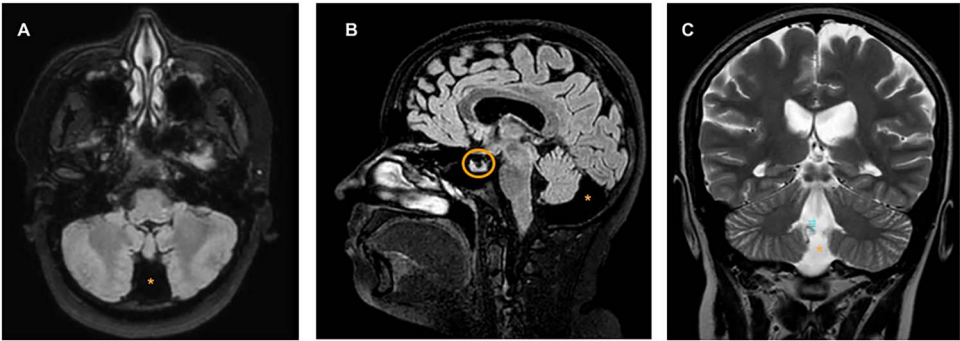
Brain magnetic resonance imaging without contrast axial fluid-attenuated inversion recovery (FLAIR) (A), sagittal T1-weighted (B) and coronal T2-weighted (C) images demonstrate mega cisterna magna (asterisk), an enlargement of the cerebrospinal fluid-filled subarachnoid space in the inferior and posterior portions of the posterior cranial fossa. B, Sagittal view showing an empty sella (circle).
